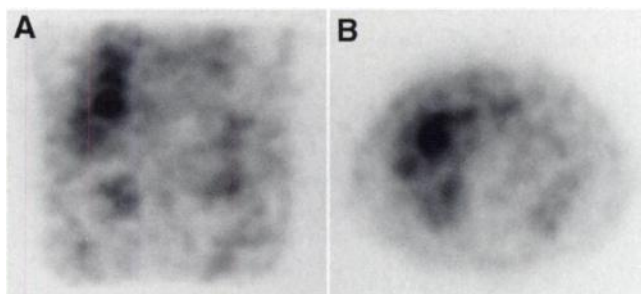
Selected coronal (A) and transverse (B) views (FDG) of 66-y-old man with metastatic lesion in liver from colon carcinoma. Images were acquired in 30 min in two-dimensional mode with dual-head scintillation camera operating in coincidence mode.
